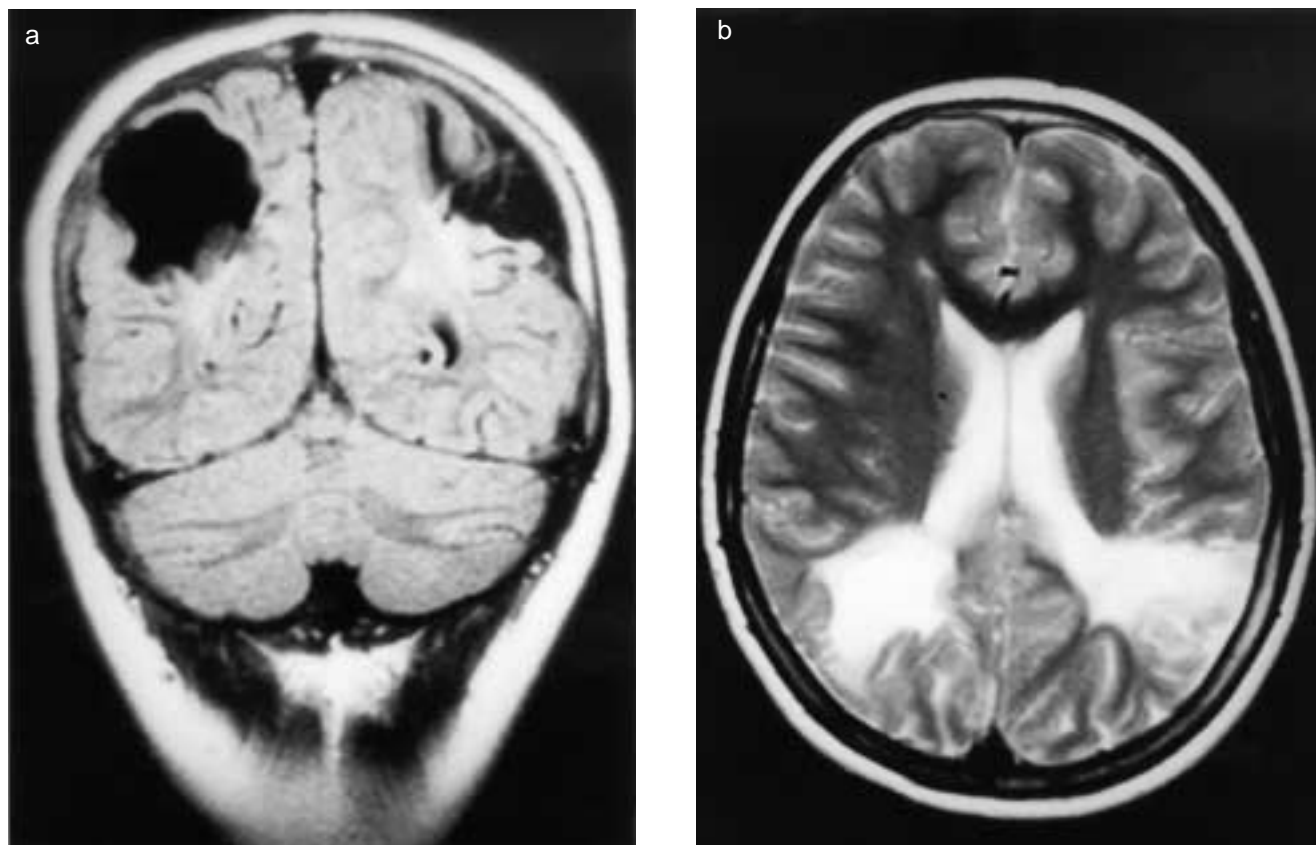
MRI of (a) coronal section and (b) transverse view of patient's brain showing infarcts of both parietal lobes.
